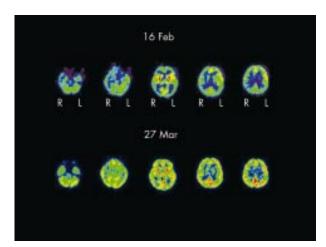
Brain PET using 18 F-fluorodeoxyglucose obtained 40 minutes after the injection. (Top) Selected transaxial PET images of the brain during the height of the patient's deterioration showed diffusely decreased, non-uniform FDG uptake in the brain, most severely affecting the right parietal, the right temporal, and the left inferior frontal areas. The FDG uptake in the basal ganglia and the thalamus were comparatively well preserved. (Below) Transaxial PET images of the brain after the patient's clinical improvement demonstrated symmetric distribution of FDG suggesting a significant improvement of the cerebral glucose metabolism compared with the previous study.
